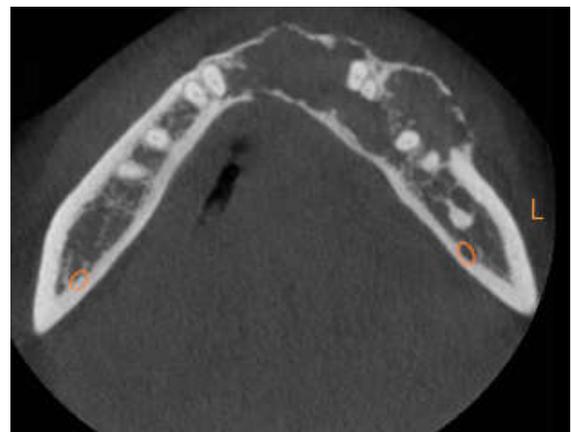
Expansion and perforation of buccal, labial and lingual cortical plates (CBCT axial section)
